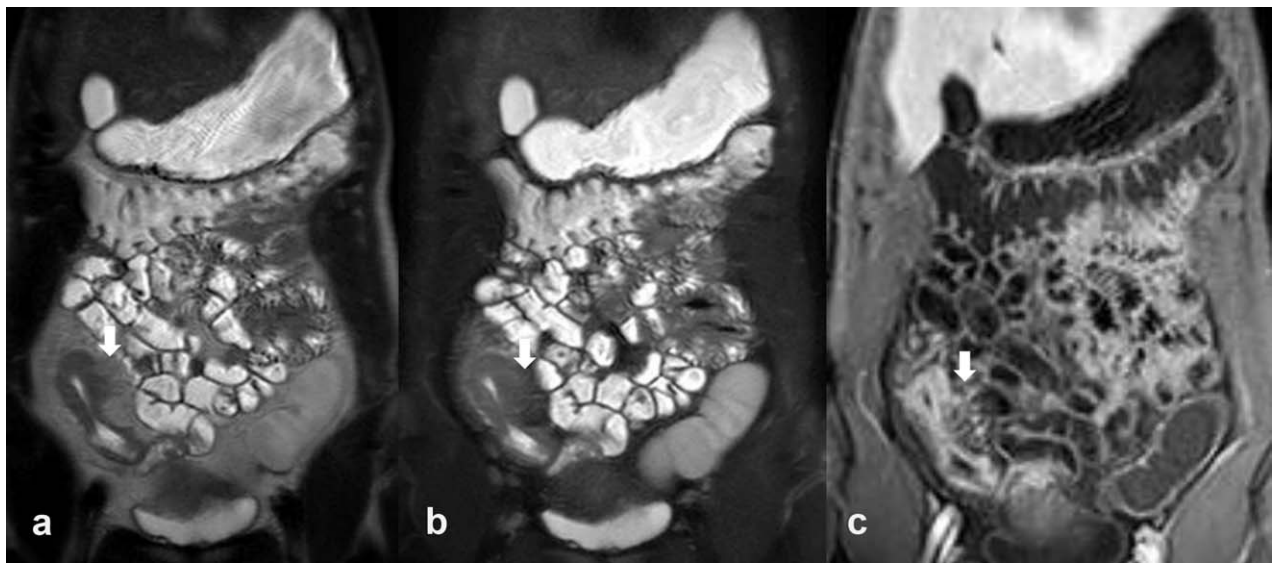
A 35-year-old woman patient with active CD. (a) TSE T_2 -weighted MR images; (b) T_2 -weighted SPAIR MR images with fat suppression; (c) THRIVE with fat suppression MR images acquired in the coronal plane after injection of gadobenate dimeglumine during the arterial phase. Diffuse thickening of the terminal ileal loop with evidence of sinus tracts (arrow) correctly identified at T_2 -weighted images (a,b) by both readers but not clearly identified at contrast-enhanced MRE. Even though there was disagreement in identifying sinus tract, there was not disagreement between unenhanced and contrast-enhanced MRE in defining the presence of active inflammatory disease due to presence of transmurular enhancement corresponding to active inflammation at endoscopy (CDEIS = 14)
